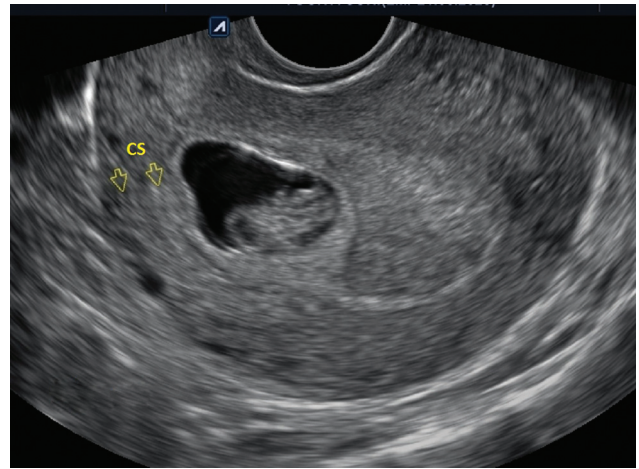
TVUS at 7 weeks of gestation: The gestational sac is lying near the CS scar. No thinning of the anterior myometrium; a sliding sign was present suggesting ongoing miscarriage. Previous CS scar (arrows). CS, cesarean section; TVUS, transvaginal ultrasound.
